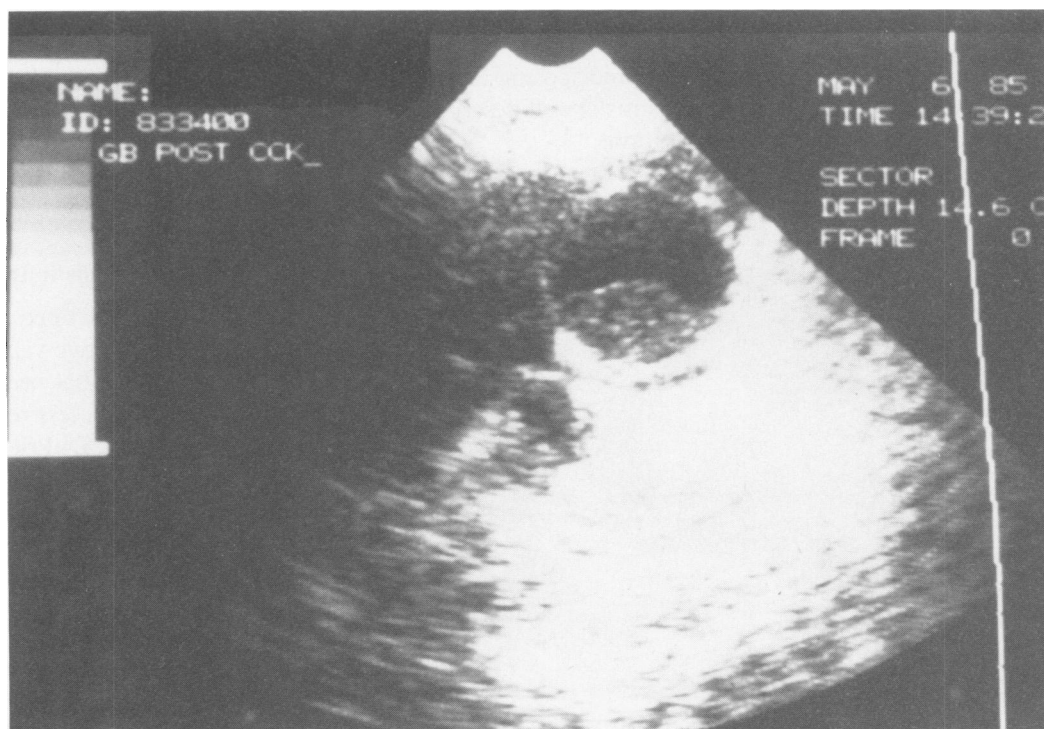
Ultrasound demonstrating thickened gallbladder wall and sloughed mucosal membrane.
